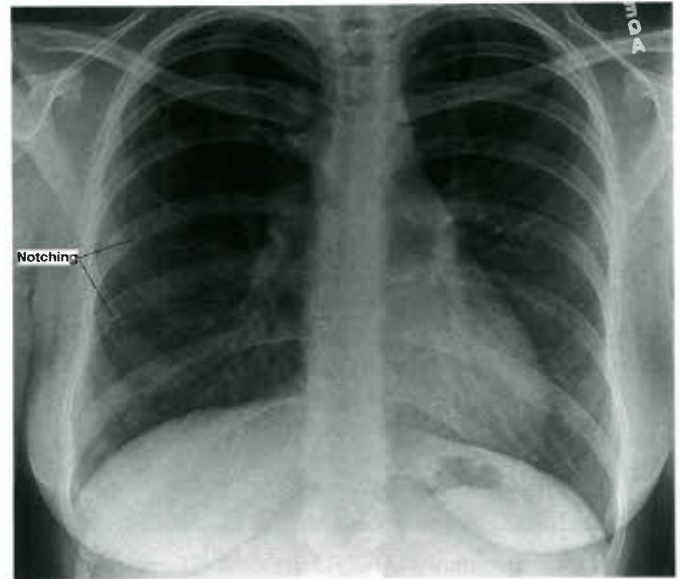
Chest radiograph of a woman with unrepaired coarctation demonstrating rib notching from dilated and tortuous intercostal arteries.
